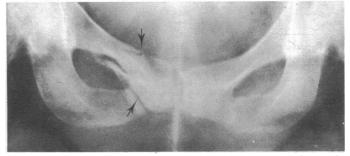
Case 1. X-ray film of pubic rami showing Looser's zones (arrowed).
